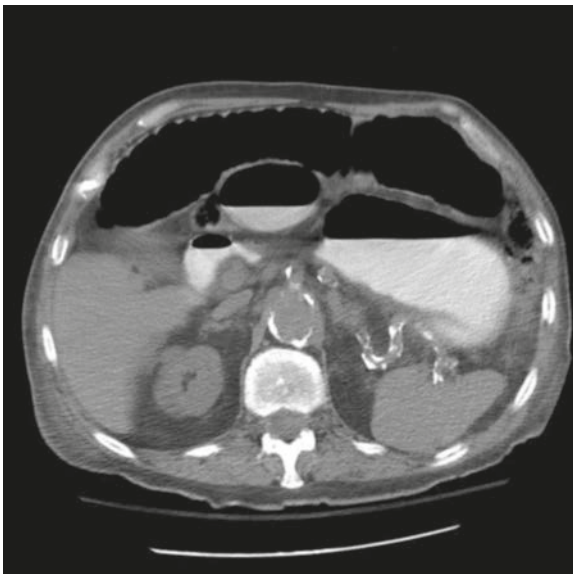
Damage control laparotomy. This 57-year-old man with coronary artery disease and dialysis-dependent chronic renal failure presented with septic shock and CT evidence of right colon ischaemia. He was managed emergently by laparotomy to resect the ischaemic colon, leaving the ends of the viable intestine stapled off, and the abdomen open. Two days later, and following haemodynamic stabilization, re-exploration was undertaken, and an anastomosis created between the two ends of defunctional bowel. A further 2 days later the abdomen was closed.
